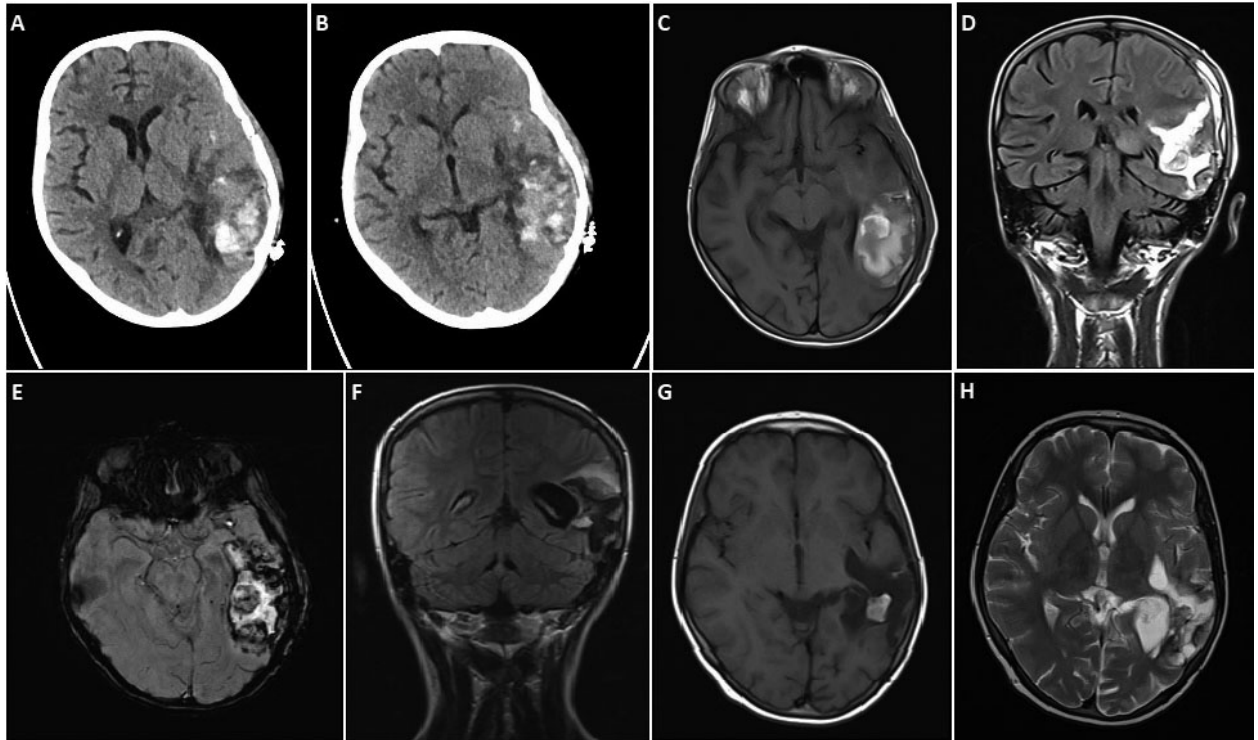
In a 12-year-old girl, cranial computerised tomography demonstrates acute haemorrhage in left temporal lobe (A, B). Fifteen days after evacuation of haematoma, axial T1-weighted and coronal fluid attenuated inversion recovery images show haemorrhage and haematoma (C, D). Axial susceptibility-weighted imaging shows haemorrhage in acute-subacute period (E). After 8 months, coronal fluid attenuated inversion recovery, axial T1-weighted, and axial T2-weighted, images show enlarged occipital horn of left lateral ventricle, porencephaly, and gliotic changes in cerebral parenchyma (F–H)
